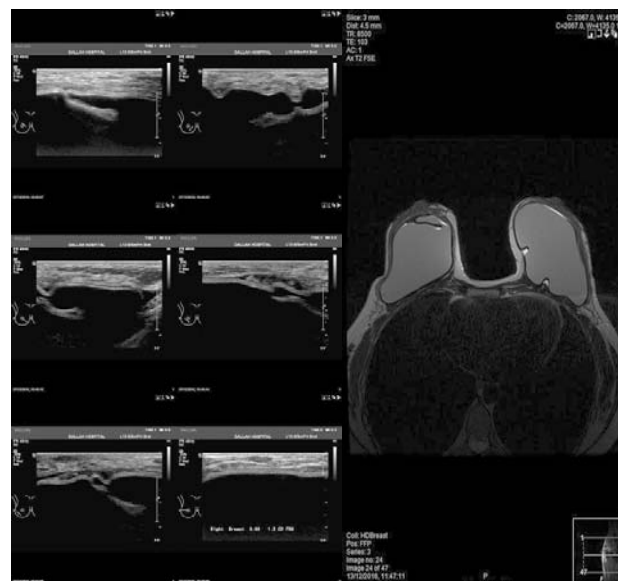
Ultrasound breast showing subcapsular fluid and intraluminal membrane due to intracapsular rupture. MRI confirms the findings of ultrasound.
